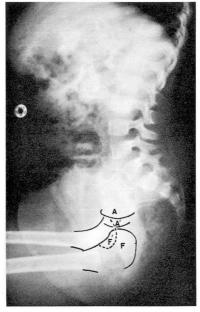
Lateral roentgenogram of the pelvis. The femoral head (F) should rest in contiguity with the acetabulum (A). F¹ indicates the contralateral femoral head, and A¹ the corresponding acetabulum.
